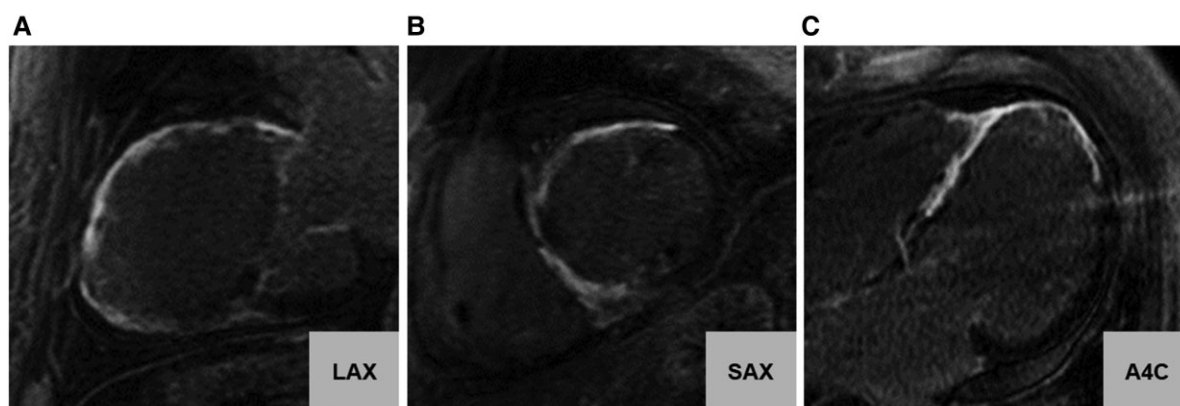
Cardiac magnetic resonance imaging displaying increased late gadolinium enhancement extending from the basal anteroseptal and inferoseptal areas to the anteroapex and inferoapex of the left ventricle. (A), (B), and (C) show the long-axis, short-axis, and apical four-chamber views, respectively. LAX, long-axis view; SAX, short-axis view; A4C, apical four-chamber view.
